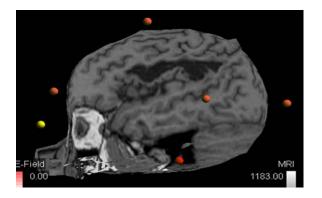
Lateral view of A.K.'s current MRI scan revealing involvement of the left posterior frontal lobe.
